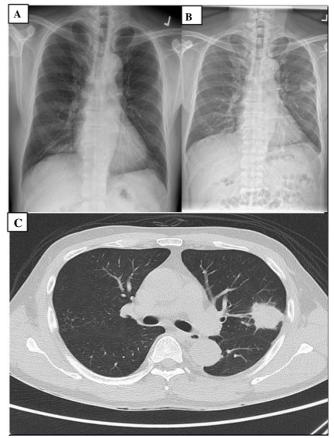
Radiographic images including previous and presenting chest radiographs, as well as a coronal view on CT scan of the pulmonary Nocardial lesion of the febrile middle-aged man. A: Chest radiograph 3 months prior to presentation, prior to commencement of corticosteroids. B: Left middle zone opacification at presentation. C: Spiculated mass in the left upper lobe corresponding to the opacity detected on chest radiograph.
